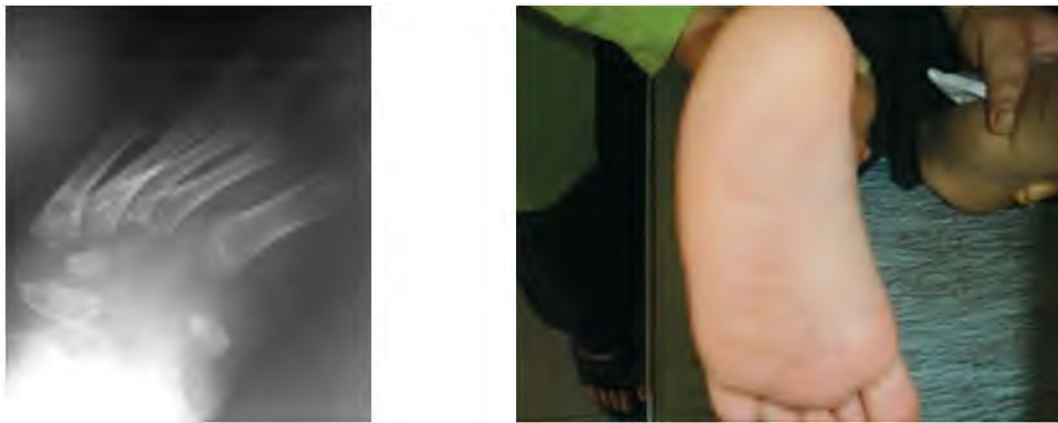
Shows a foot with slipping of the bone graft as evident radiographically and clinically.
